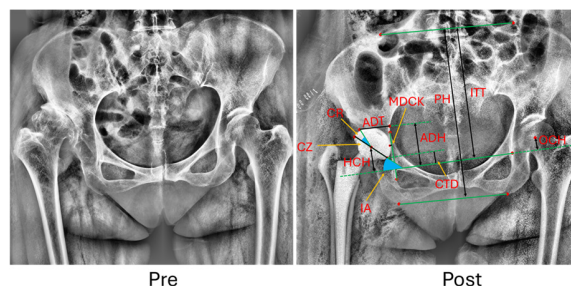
Parameters measured on pelvic radiographs.
